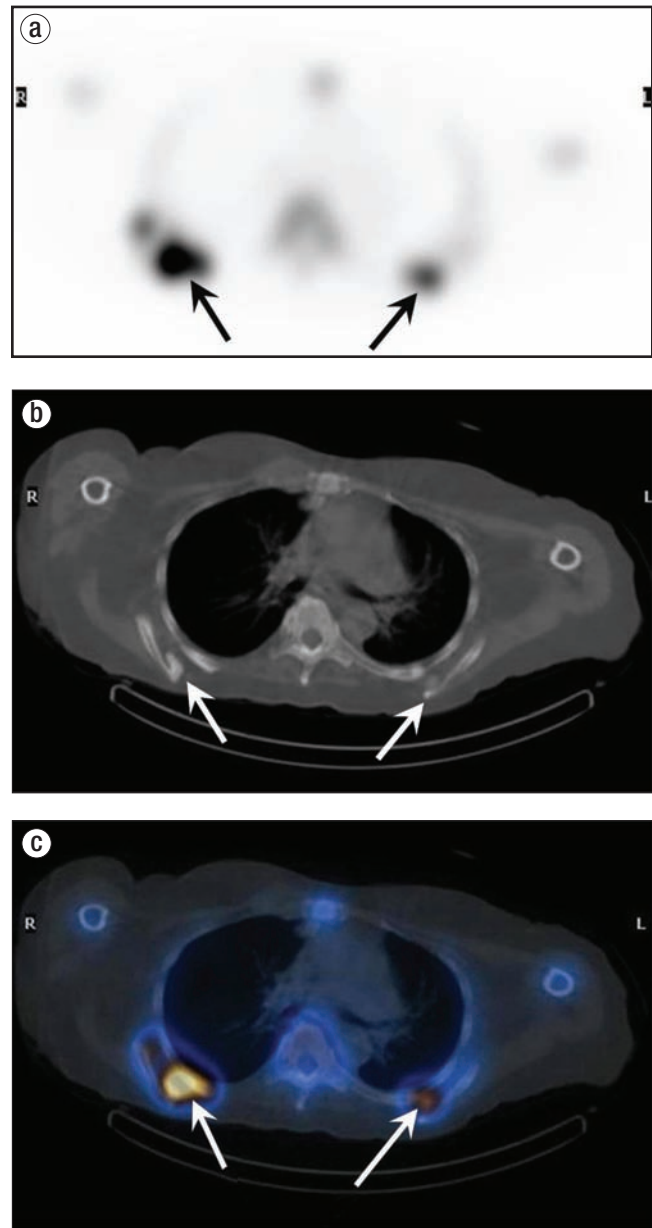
(a) Transversal SPECT, (b) low-dose CT, and (c) fusion images from SPECT/CT through the chest at the level of the scapulae demonstrate areas of increased tracer activity corresponding to osseous projections, or exostoses, off the scapulae (arrows) in this patient with voriconazole-induced periostitis.
